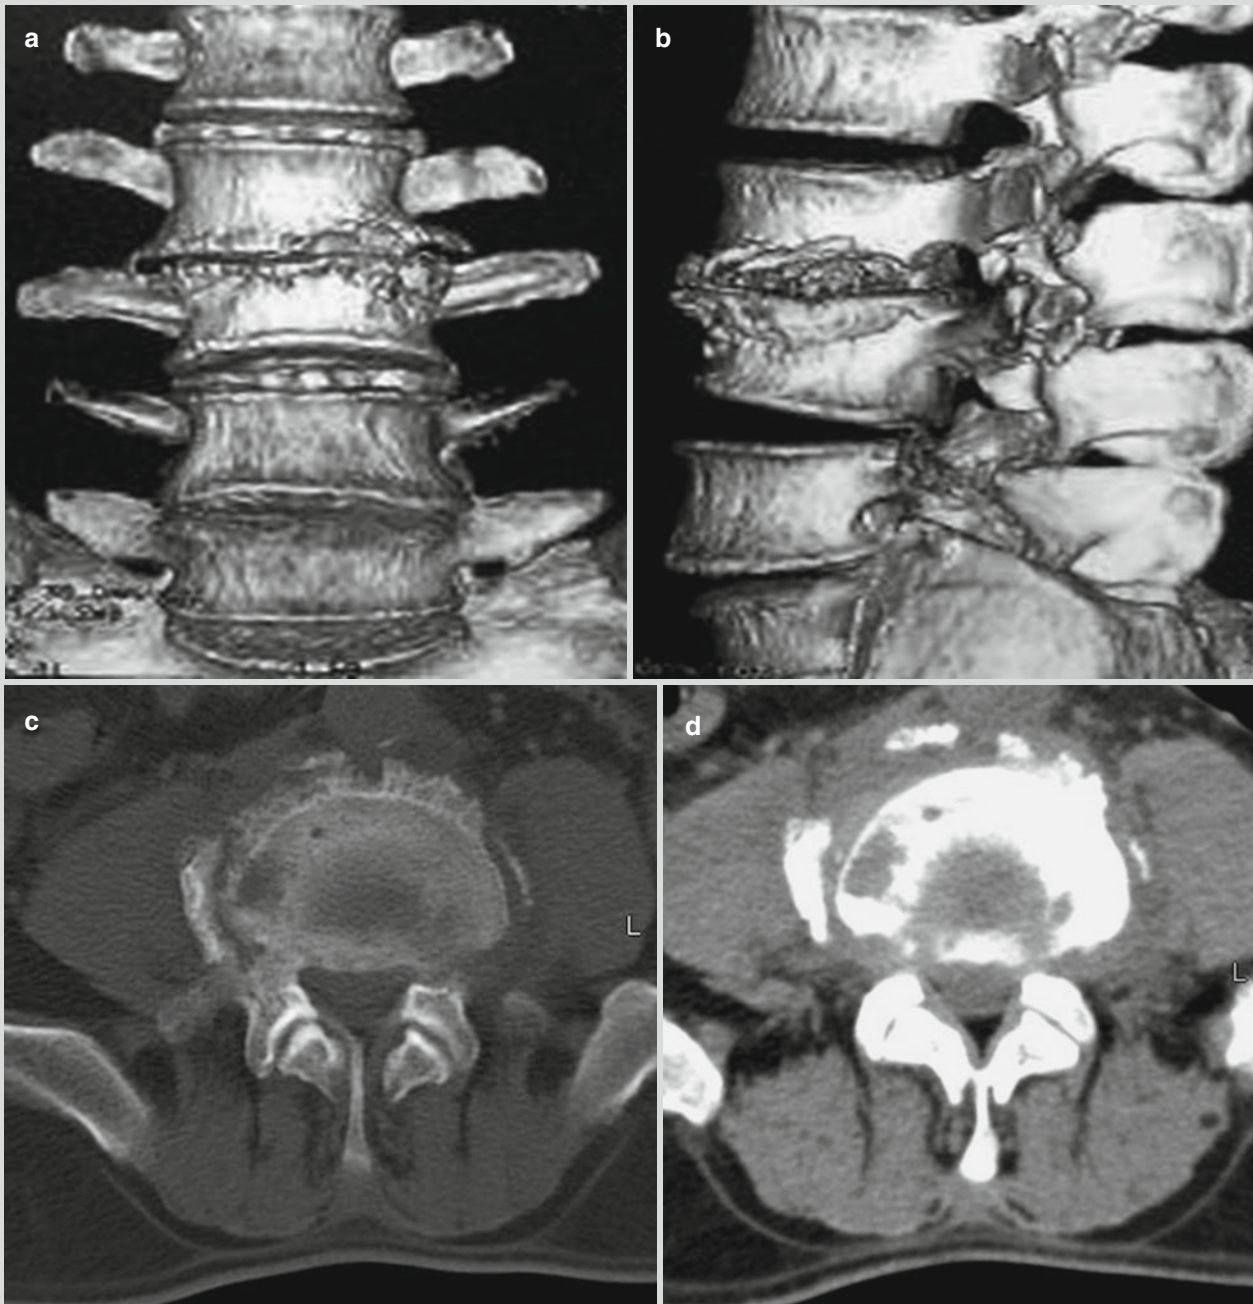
Brucellar spondylitis. (a–d) CT scanning demonstrates osteoproliferation and bone destruction at the lumbar vertebrae, with narrowed intervertebral space. The vertebral margin is demonstrated with proliferation, hypertrophy, and ossification of the periosteum to form liplike or bank-like osteophytes. The newly formed osteophytes and the destructive lesions between them constitute
